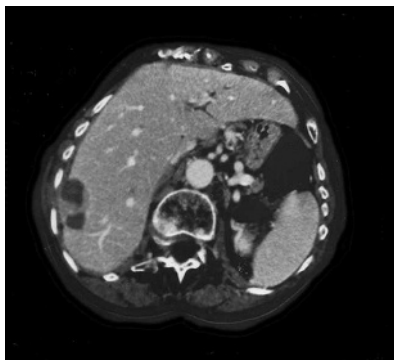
Computed tomography (CT) scan, one month after radiofrequency thermal ablation. The lesion appears to be partially treated with no clearcut residual activity in the arterial CT phase.
